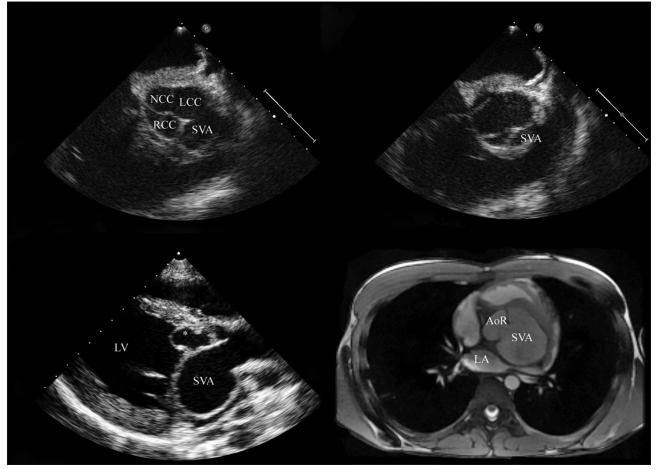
Transesophageal echocardiography of the aortic root (short axis view) demonstrates the orifice of the left-side sinus of Vasalva aneurysm (SVA) during diastole and systole (upper-left and upper-right panels). Transthoracic echocardiography (parasternal long axis, diastole) shows the large SVA bulging into the left atrium, displacing the anterior mitral valve leaflet toward the apex of the ventricle (lower-left panel). A smaller secondary aneurysm bulges toward the left ventricular outflow tract. (*) Cine cardiovascular magnetic resonance (transverse slice, 8 mm slice thickness, 3 T) reveals the SVA, originating from the left coronary sinus, bulging into the left atrium. AoR = aortic root; LA = left atrium; LV = left ventricle; LCC = left coronary cusp; NCC = noncoronary cusp; RCC = right coronary cusp
